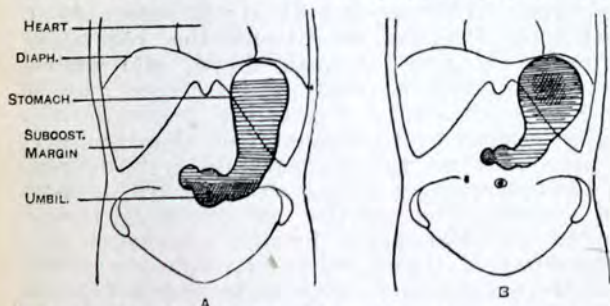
Radiographic outline of the stomach of a patient who has taken a bismuth-laden diet. (After Dr. A. F. Hurst.)
